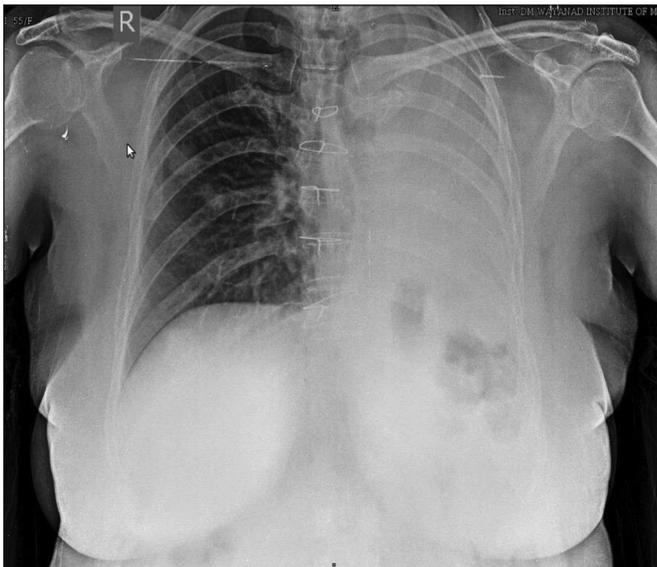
X-ray chest PA (incomplete film) showing left lung collapse. There is a small ill-defined opacity in the right mid-zone. Sternal wires due to previous thoracotomy are visible.
